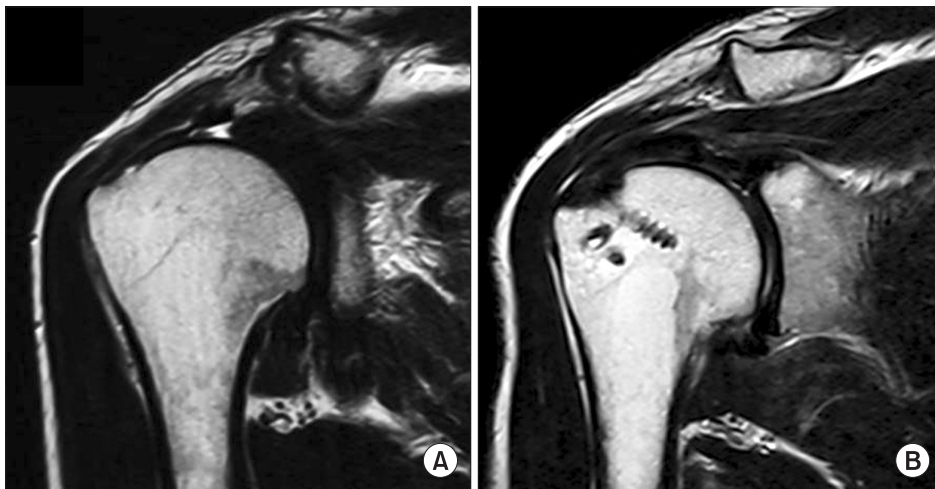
(A) Preoperative T2-weighted coronal magnetic resonance image shows rotator cuff tear. (B) One-year postoperative magnetic resonance image shows healed rotator cuff.
